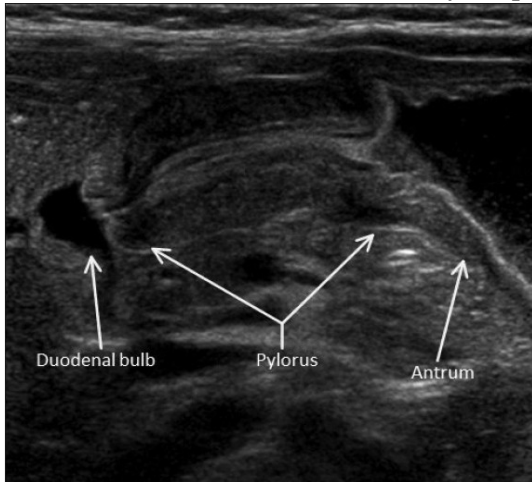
Ultrasound Abdomen -Hypertrophic Pyloric Stenosis
